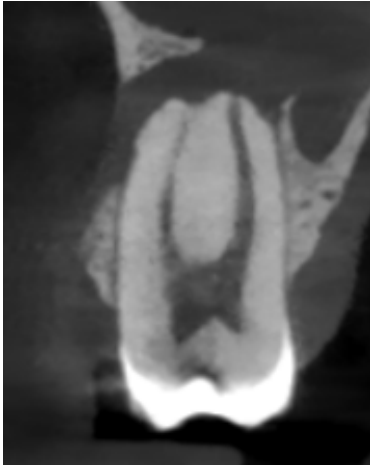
The CBCT revealed two canals: a broad vestibular canal and a palatal canal, with the apex of the palatal root being notably open.
